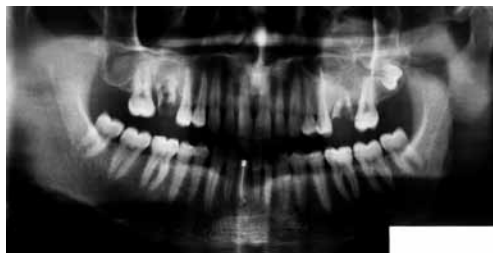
Panoramic Xray showing a radiolucent lesion with radio-opaque rim extending from the 2.4 to the 2.8 teeth.
